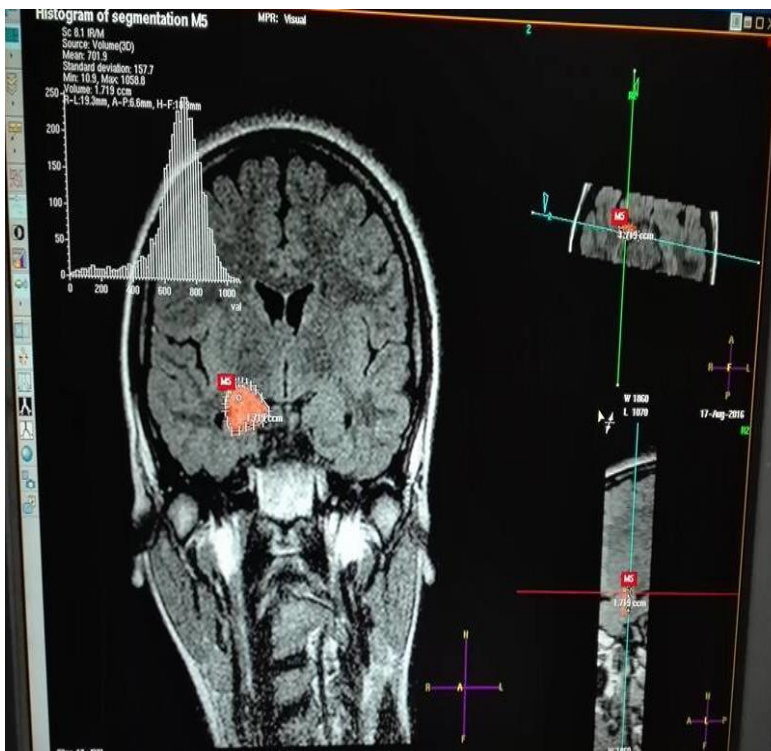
{Case no.1} Coronal FLAIR image showing bilateral hippocampal atrophy. Volume of left hippocampus is 1.367 and volume of right hippocampus is 1.719.
